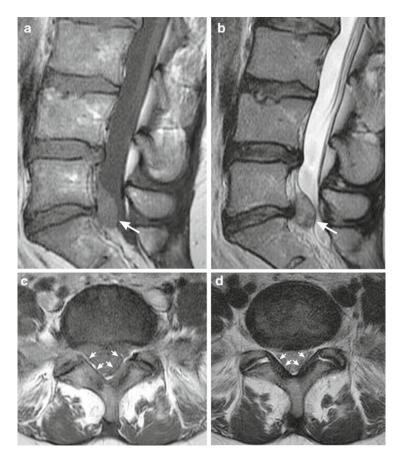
Very large disk extrusion which caused sciatica without neurological deficit. A 44-year-old woman presents with left S1 radicular pain without neurological deficit. T1 (a)-weighted and T2 (b)-weighted sagittal MRI images and T1 (c)-weighted and T2 (d)-weighted axial MRI images at L5 show a large disk extrusion which
